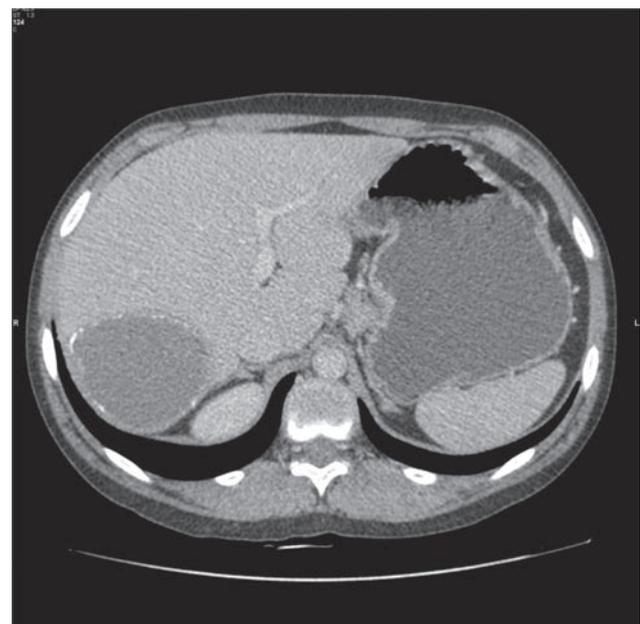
Axial contrast-enhanced CT; liver hydatid cyst, wall calcifications are noted.
